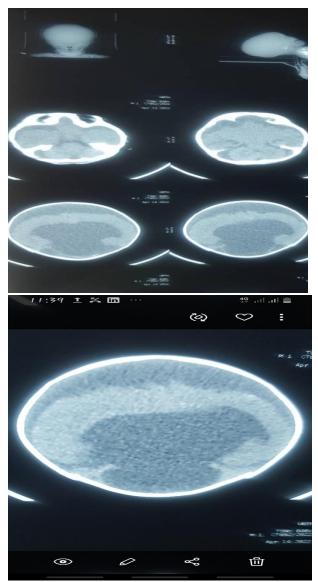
Imaging of the brain (CT scan) showing dilatation of both lateral and the third ventricles, hypoplastic cerebral hemisphere with the fusion of both frontal lobes.
